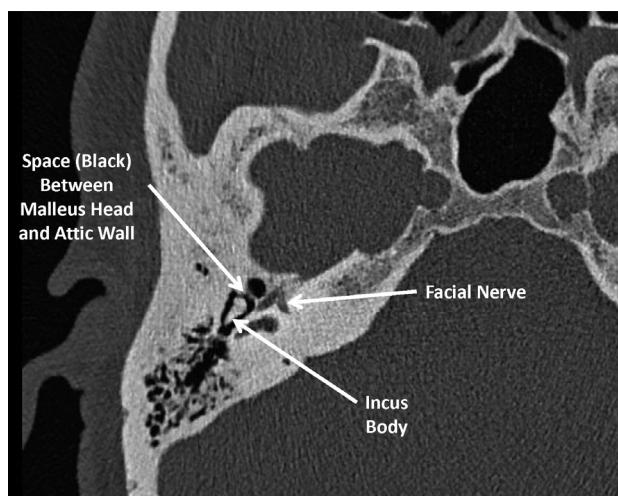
The axial CT of the right temporal bone at the level of the malleus head and incus body showed a small space between the malleus head and the epitympanic (attic) wall.
